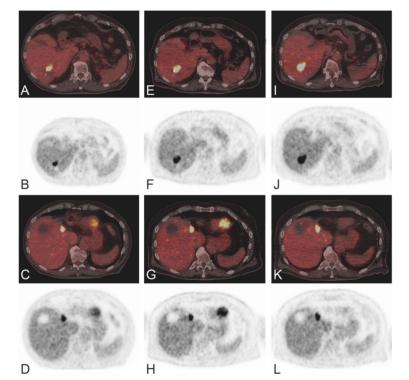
Response monitoring liver metastases. PET/CT (A, C, E, G, I, K) and PET (B, D, F, H, J, L) images before (A-D), after 3 cycles (E-H) and after 6 cycles (I-L) of capecitabine treatment.
